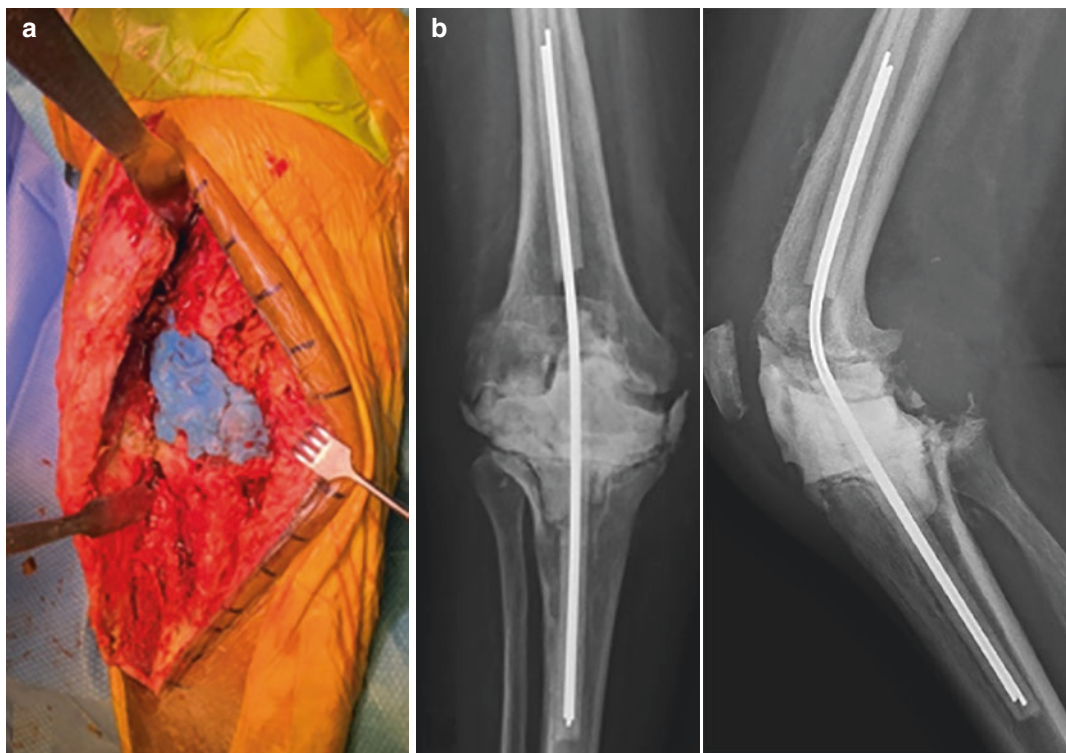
(a) Perioperative photo of a static spacer with methylene blue denatured cement. (b) Postoperative radiograph after insertion of the static spacer reinforced with Kirschner wires
